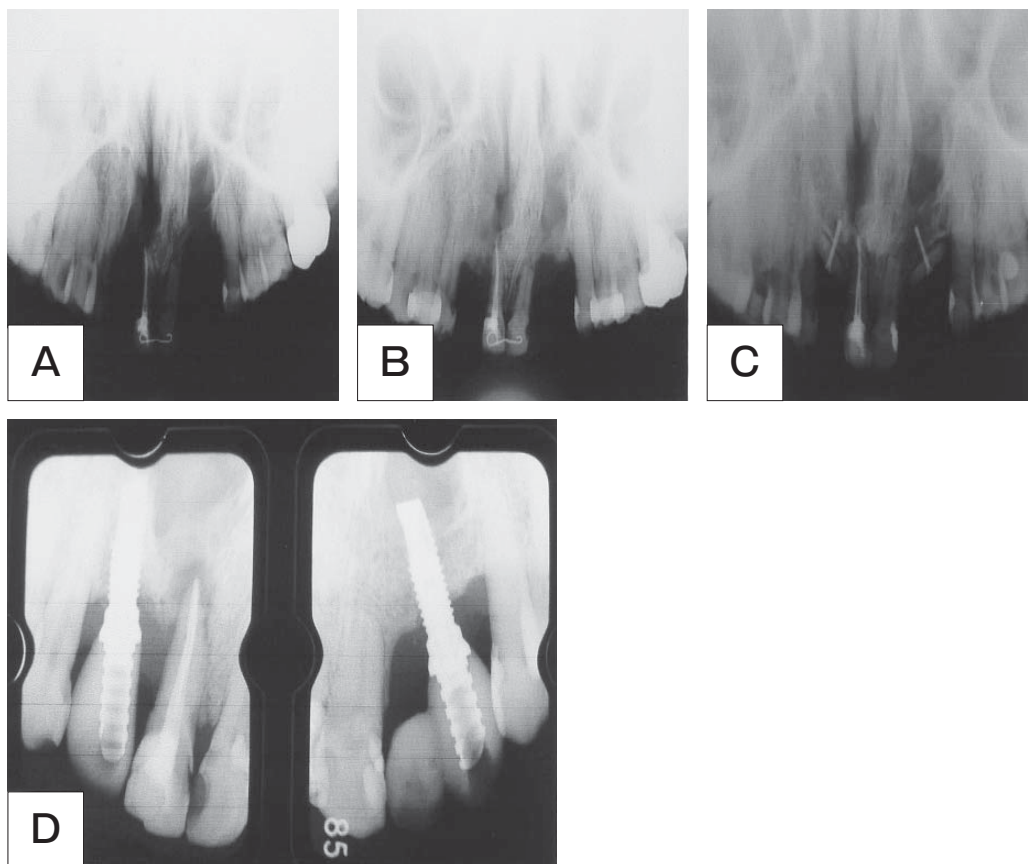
A series of radiograph pictures of the patient. A, Radiograph before alveolar graft. Bilateral alveolar clefts are seen; B, Radiograph after autogenous particle cancellous bone marrow (PCBM) grafting to alveolar cleft; C, Radiograph after mandibular ramus onlay graft (RBOG); D, Radiograph of prosthesis at 2 years after implant installment. The radiolucent area of the right incisor is a periapical lesion, which is not related to the implant surgery.
